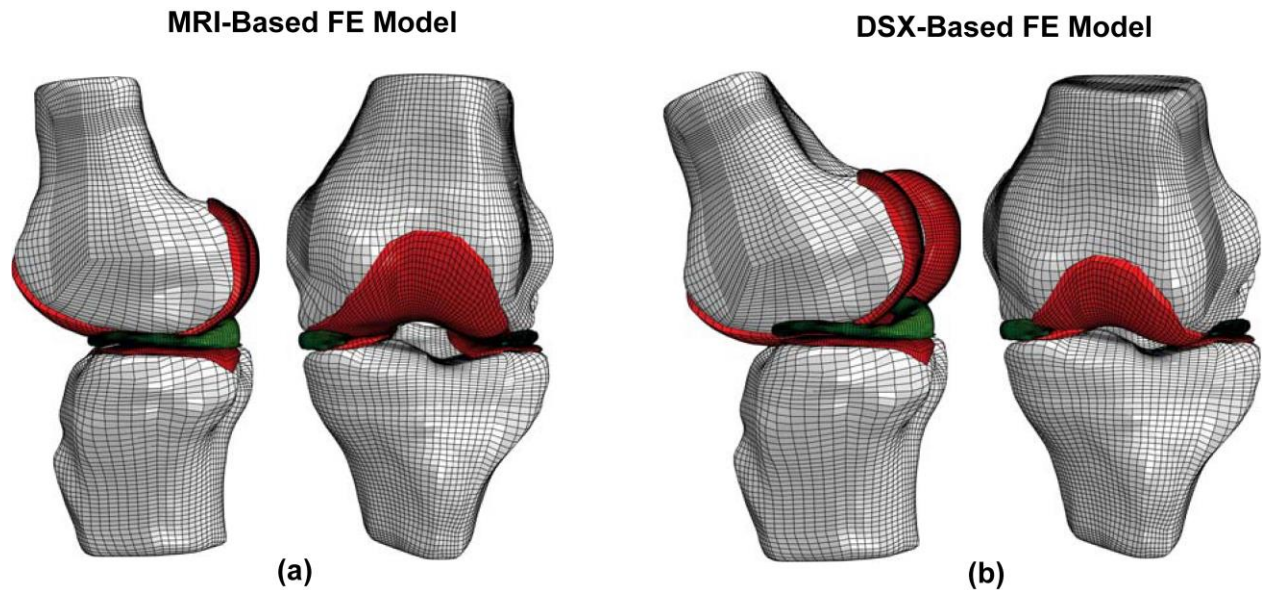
Lateral and anterior views of FE models of the meniscectomized knee in (a) MRI-based and (b) DSX-based positions.
